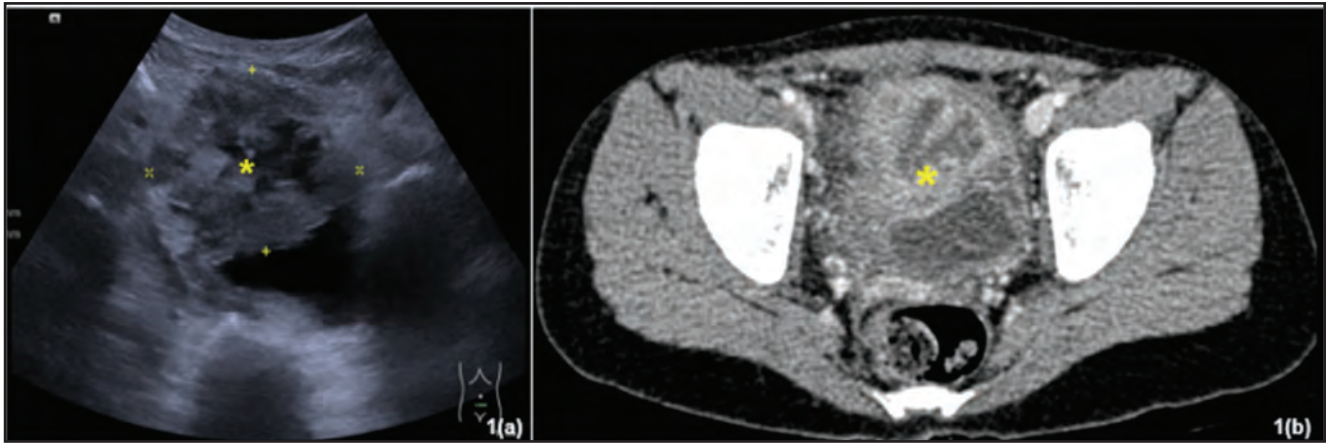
Preoperative abdominal ultrasonography showing a pelvic mass at the superior aspect of the bladder dome (a) and the solid lesion was confirmed on the contrast enhanced computerized tomography of the abdomen (b)
